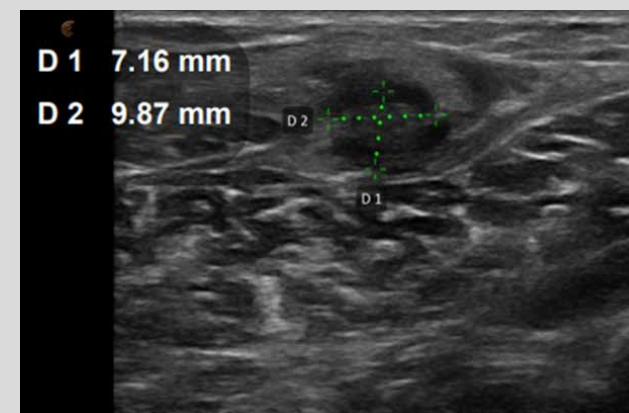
Ultrasound 5 weeks after injury
